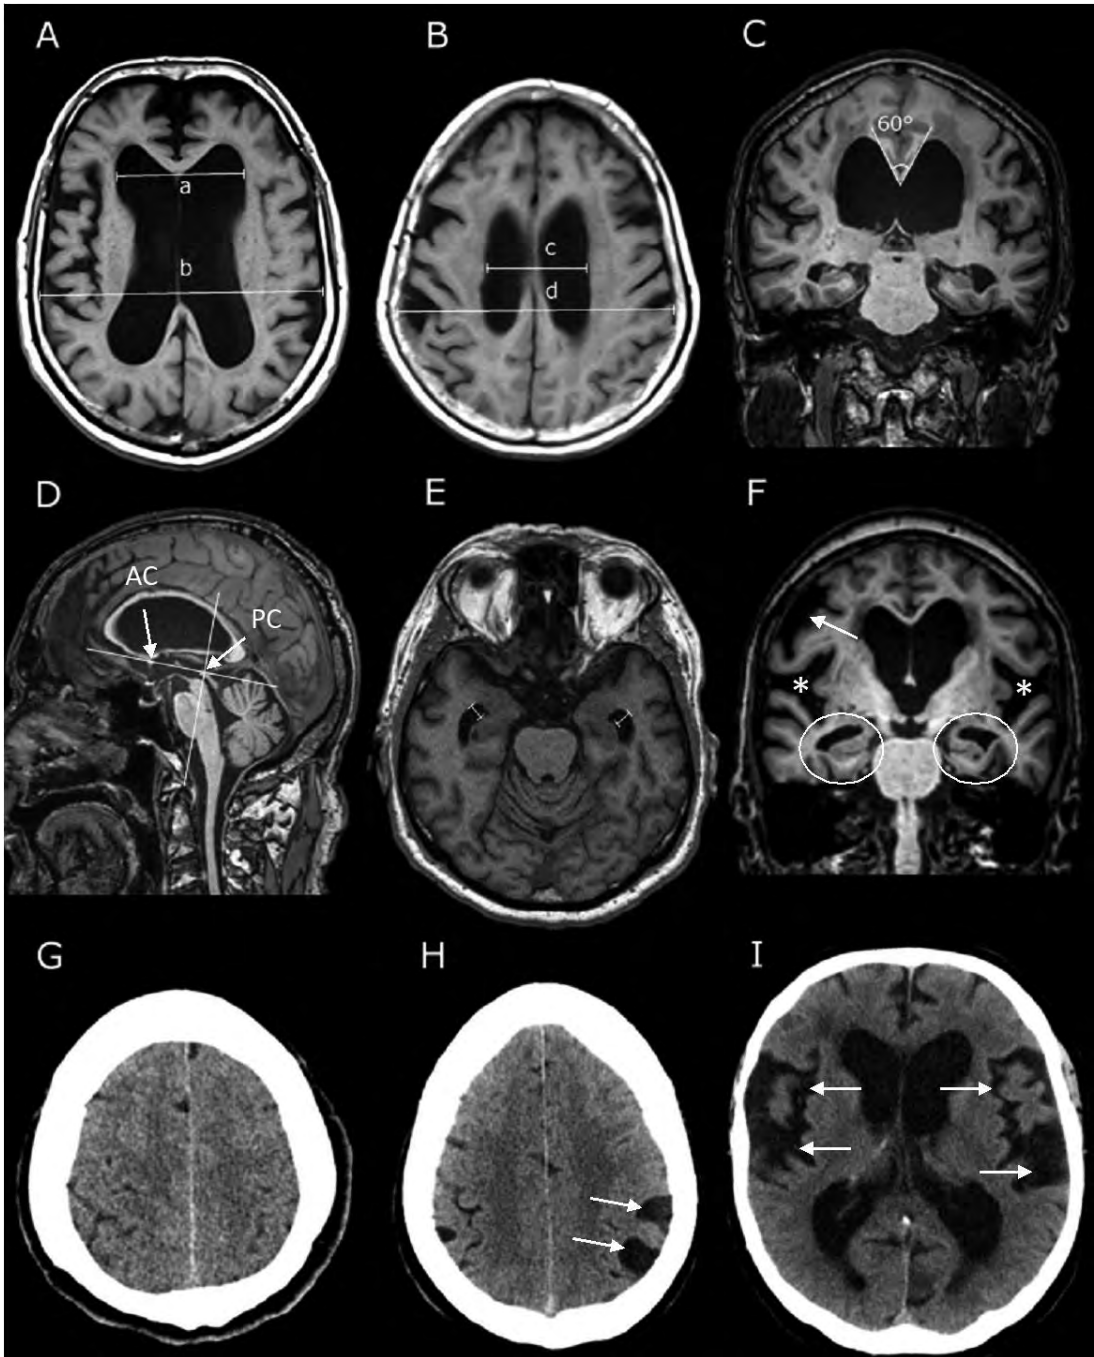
The radiological markers used in iNPH and differential diagnostics. A. Evan's index = a/b . B. Modified cella media index = c/d . C and D. Callosal angle 60°, coronal and sagittal planes, T13D 3-T MRI. The angle is measured on a coronal plane (C) perpendicular to the anterior commissure (AC) - posterior commissure (PC) line at the level of the PC (D). E. Enlarged temporal horns, axial T13D 1.5-T MRI. F. Disproportionally enlarged subarachnoid spaces (severe); enlarged Sylvian fissures (*) and lateral ventricles, and tight high convexity. Medial temporal lobe atrophy on both sides marked by circles, Scheltens scores 2 on the patient's left and 1 on the right side. Focally dilated sulcus on the right (arrow). T13D 3-T MRI. G. Narrowed sulci over the high convexity, CT. H. Focally dilated sulci (arrows), CT. I. Severely dilated Sylvian fissures (arrows), CT.
